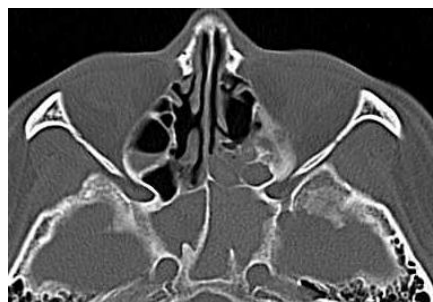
Computed tomography scans of the patient's nasal sinuses.
